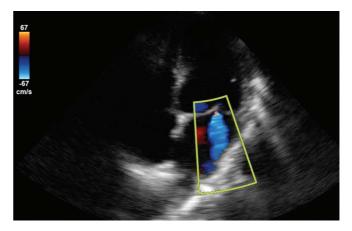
Mitral regurgitation without aliasing on color Doppler imaging. The scale has been increased in another example of mitral regurgitation so that there is no turbulent flow visualized. Note that the magnetic resonance jet is directed toward the posterior-lateral left atrial wall. In the setting of suspected endocarditis, this would imply a coaptation failure of the anterior mitral valve leaflet.
